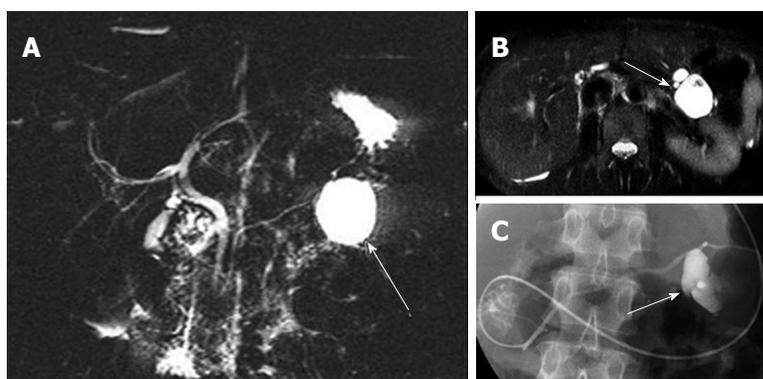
A 45-year-old female with branch duct type intraductal papillary mucinous neoplasm mimicking oligocystic serous cystic neoplasm (also see Figure 6). A: Magnetic resonance cholangiopancreatography shows a cystic mass (arrow) in the body of the pancreas. The communication with the main pancreatic duct (MPD) is not apparent even with the source images (not shown). There is no downstream MPD dilatation; B: Axial T2-weighted single-shot fast spin-echo magnetic resonance image with fat saturation demonstrates a mass showing a cyst-by-cyst pattern (arrow); C: Endoscopic retrograde pancreatography shows the cystic lesion to be opacified (arrow), representing communication with the pancreatic duct.
